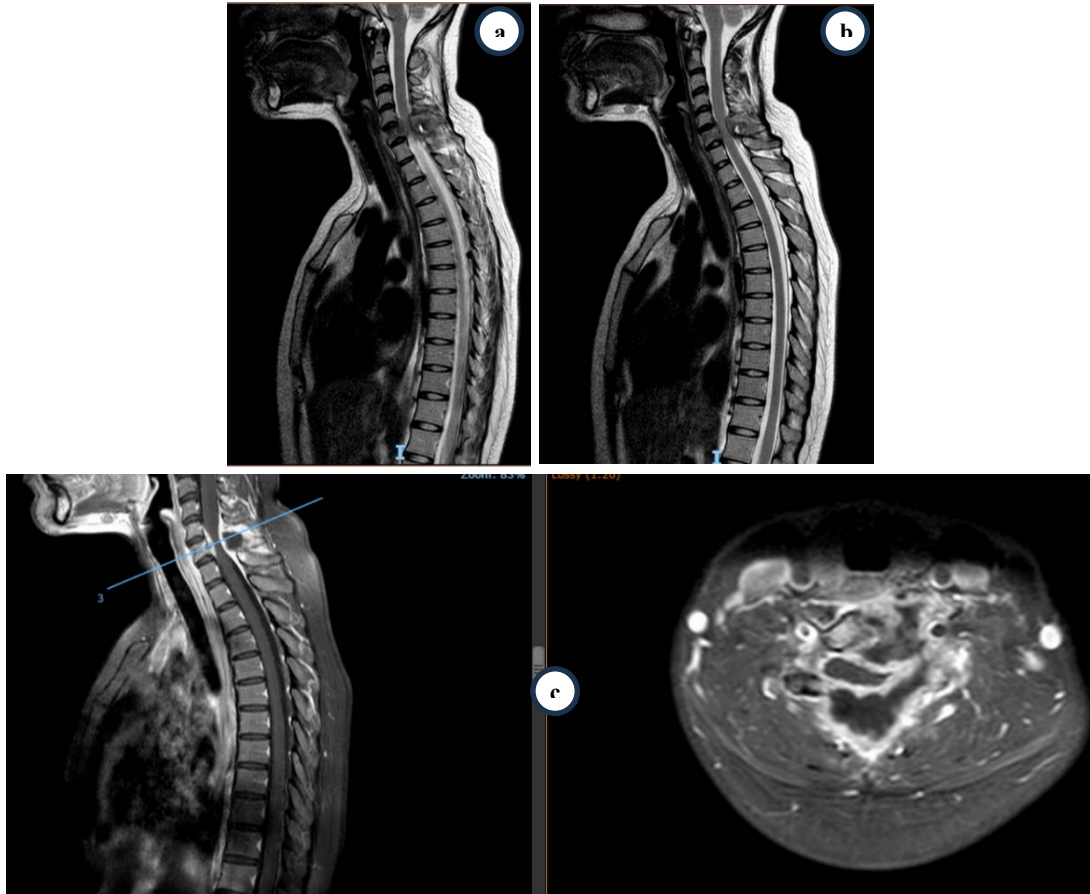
MRI cervicothoracic imaging; a and b. T2-weighted sagittal in different slices; c. T1-weighted axial and sagittal with gadolinium at the level of C6. Note that spinal cord (red arrow) was compressed by epidural and spinal canal posterior abscess
